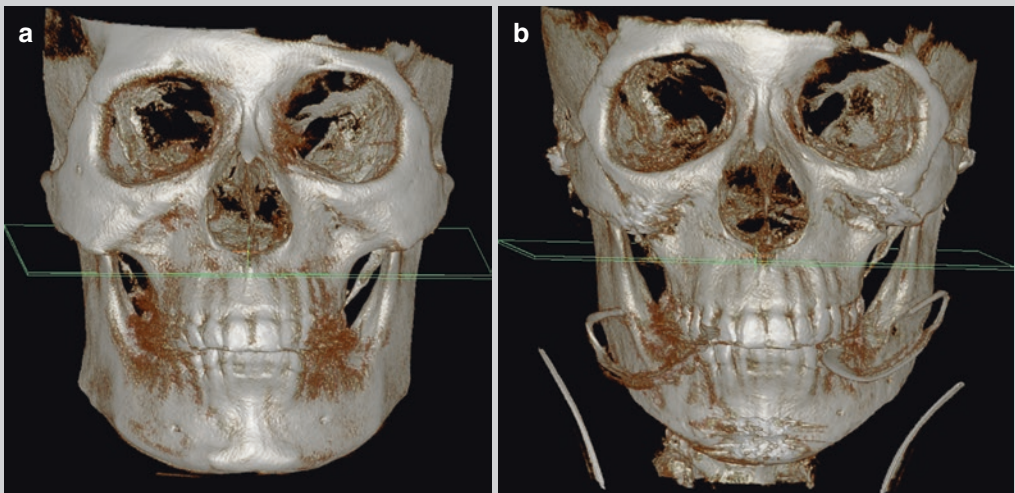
Case 2. Three-dimensional CT images: (a) preoperative and (b) postoperative
